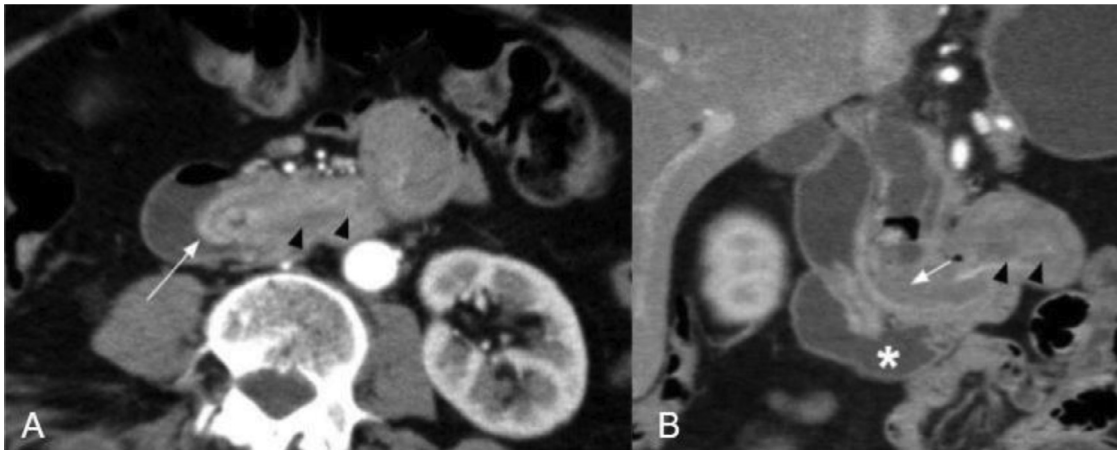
(A) Axial computed tomography (CT) scan (arterial phase). Duodeno-jejunal intussusception with a “target” sign is seen (white arrow) with contrast-enhanced tissue inside bowel lumen (black double arrowhead). (B) Coronal CT scan (arterial phase). Solid endoluminal tissue is more evident (black double arrowhead) in the duodenum distal tract, resulting in duodeno-jejunal intussusception (white asterisk) with “sausage” sign (white arrow).
